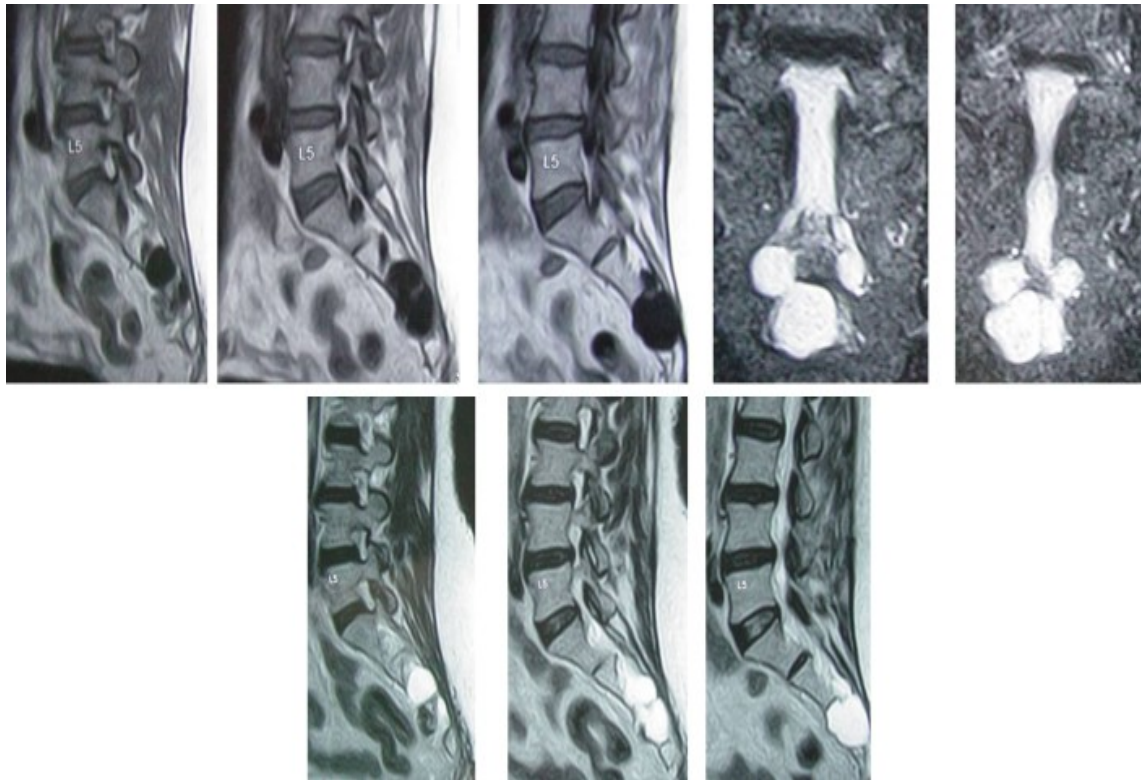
MRI showing Tarlov cyst and erosion of S3
